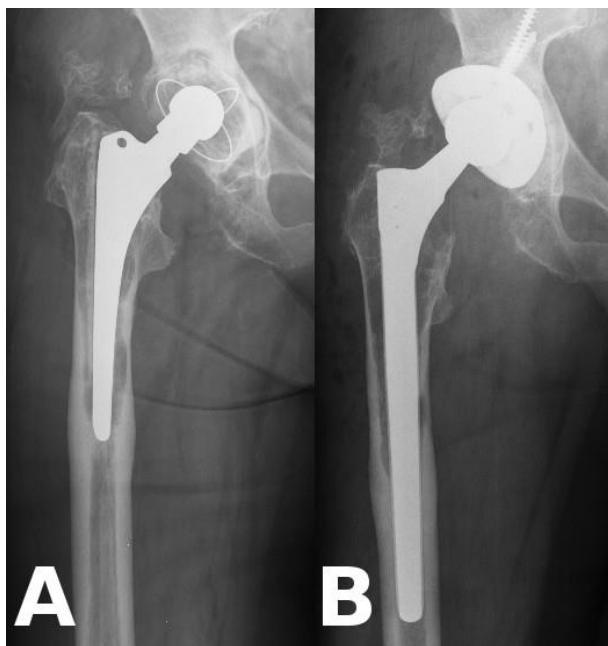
Pre- and postoperative radiographs of an AL case (Patient 11)
